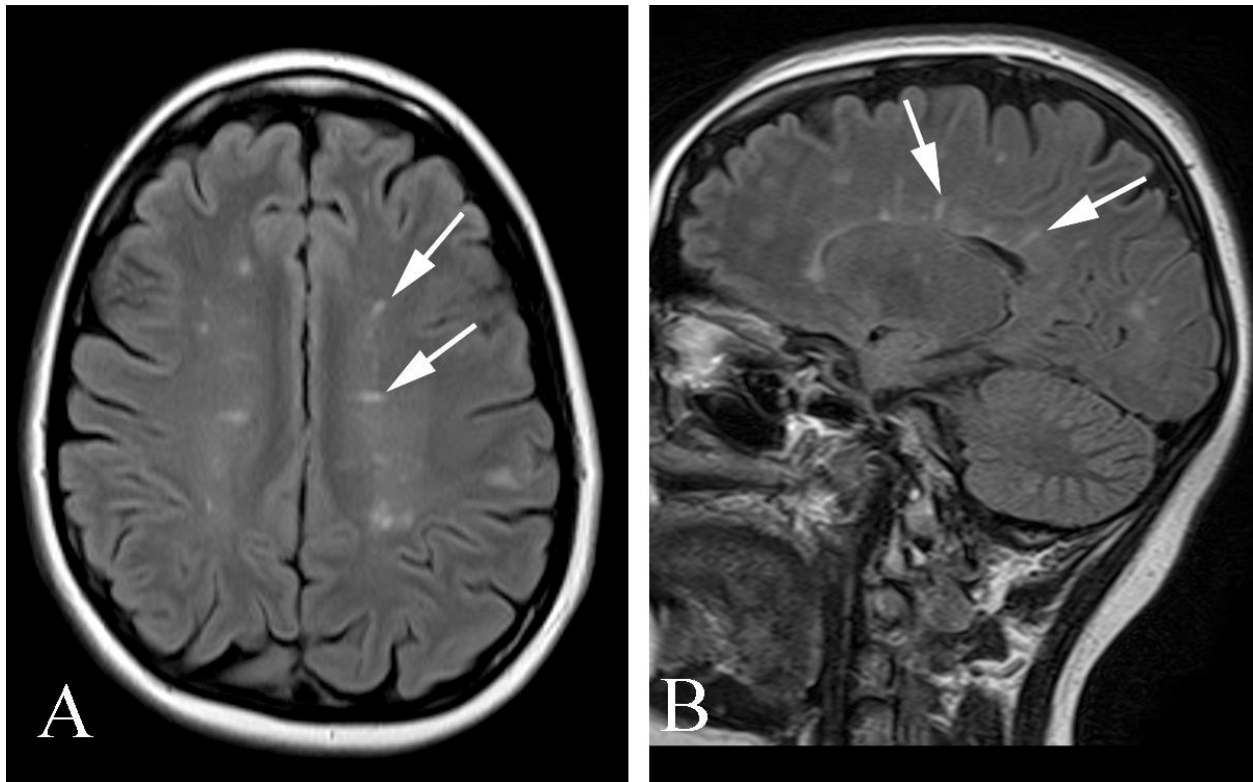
Multiple sclerosis in a 35 year old woman with blurred vision in one eye along with numbness in both hands. A. Axial FLAIR MR shows multiple foci of increased signal intensity (arrows). B. Sagittal FLAIR MR also shows multiple foci of increased signal intensity, including several lesions of the corpus callosum (arrows), typical for multiple sclerosis.
